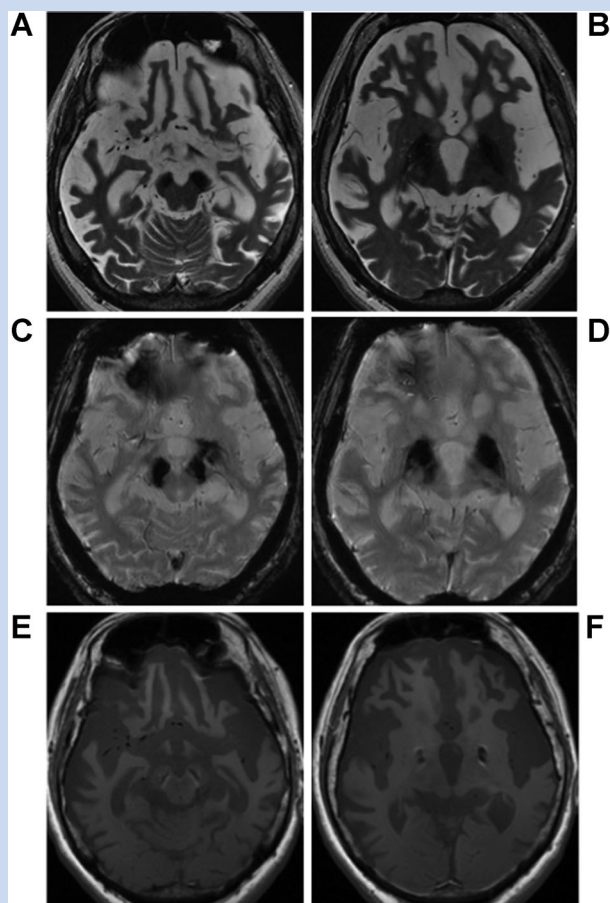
Cranial MRI images obtained at the age of 39 show severe cerebral atrophy. Markedly low signal intensities are observed in the globus pallidus and substantia nigra on fast-spin-echo T2-weighted [Panel A, B: repetition time [TR]/echo time [TE] = 4781.0/105.5 ms] and gradient-echo T2 star-weighted [Panel C, D: TR/TE = 860.0/20 ms] images. High signal intensities with central low-signal-intensity portions are observed in the substantia nigra and globus pallidus on spin-echo T1-weighted images [Panel E, F: TR/TE = 540.0/9.0 ms]. This patient underwent MRI using a 3.0 Tesla MR system [Discovery MR750, GE Healthcare, Fuchu-City, WI] with a standard head coil.
